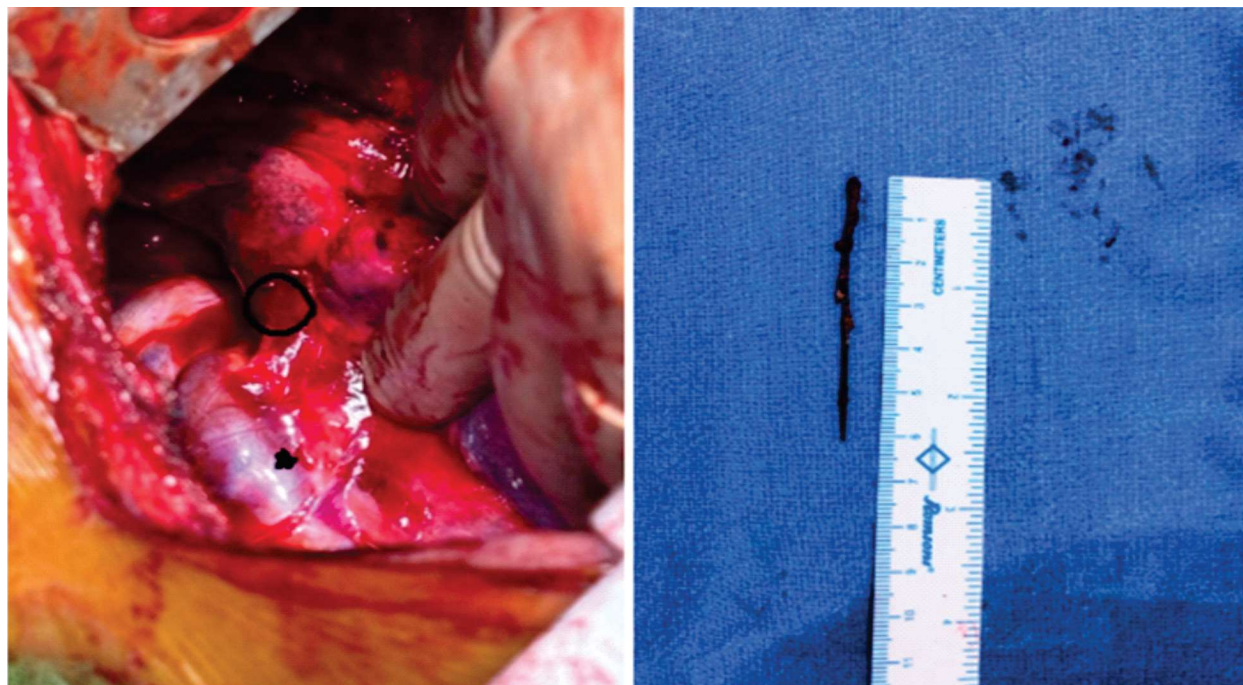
A: needle protruding out from lung parenchyma posteriorly inside circle, * (star) showing location of azygos vein, B: needle post extraction measuring 6.2 cm as seen in CT
